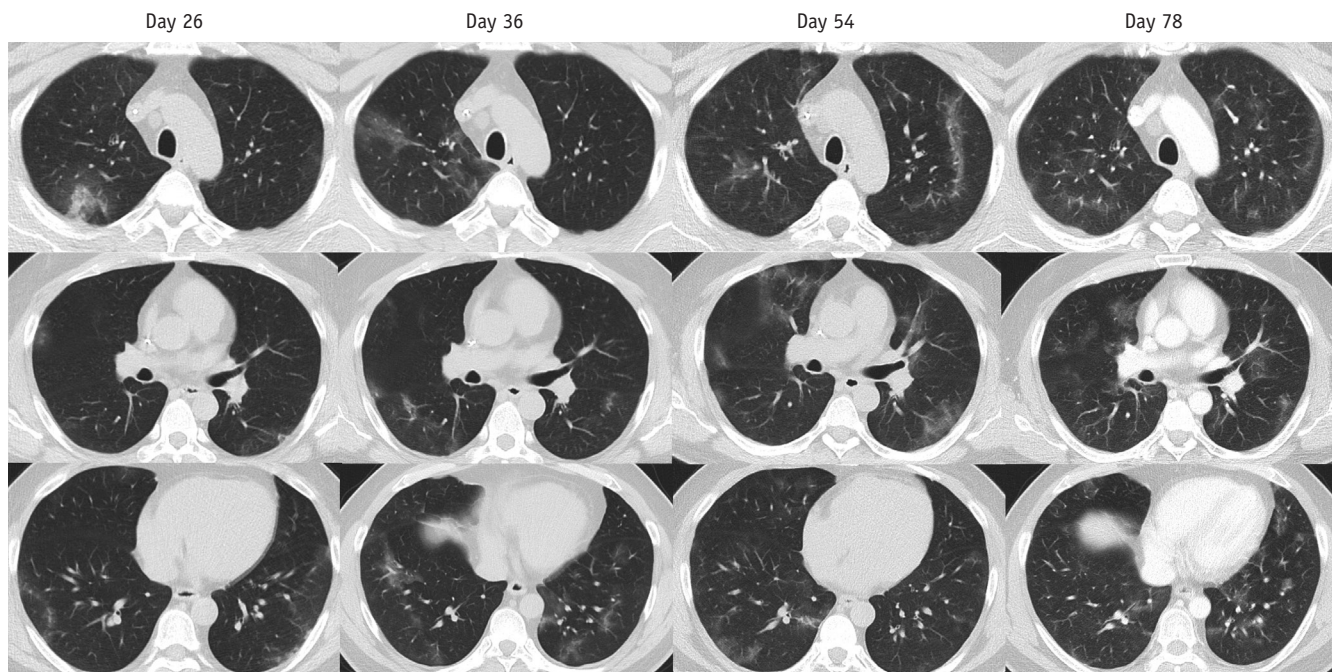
Migratory pneumonia in a 45-year-old male patient with diffuse large B-cell lymphoma and persistent SARS-CoV-2 infection. Axial chest CT images taken at 26, 36, 54, and 78 days after COVID-19 diagnosis demonstrated migration of multifocal patchy peripheral or peribronchovascular ground-glass opacities, which is clearing of previous opacities with development of new opacities in different locations. The patient had received odronextamab, a bispecific antibody that acts as a B-cell-depleting agent, 9 days prior to COVID-19 diagnosis. Reprinted from Lee et al. *Korean J Radiol* 2023;24:362-370 [7].
